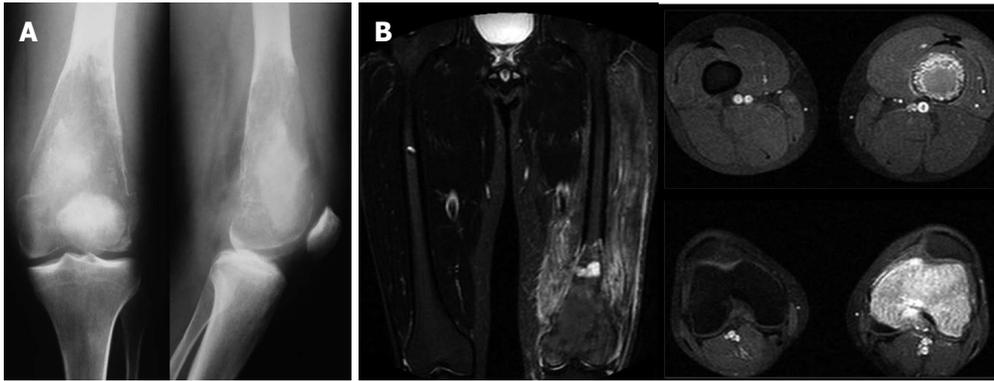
Imaging at three months after the first admission. A: Elimination of the bone trabeculation is accompanied by a compressive fracture of the metaphysis; B: Magnetic resonance imaging shows no signs of wider extension of the lesion. STIR-weight images reveal an increased oedema of the surrounding muscles.
